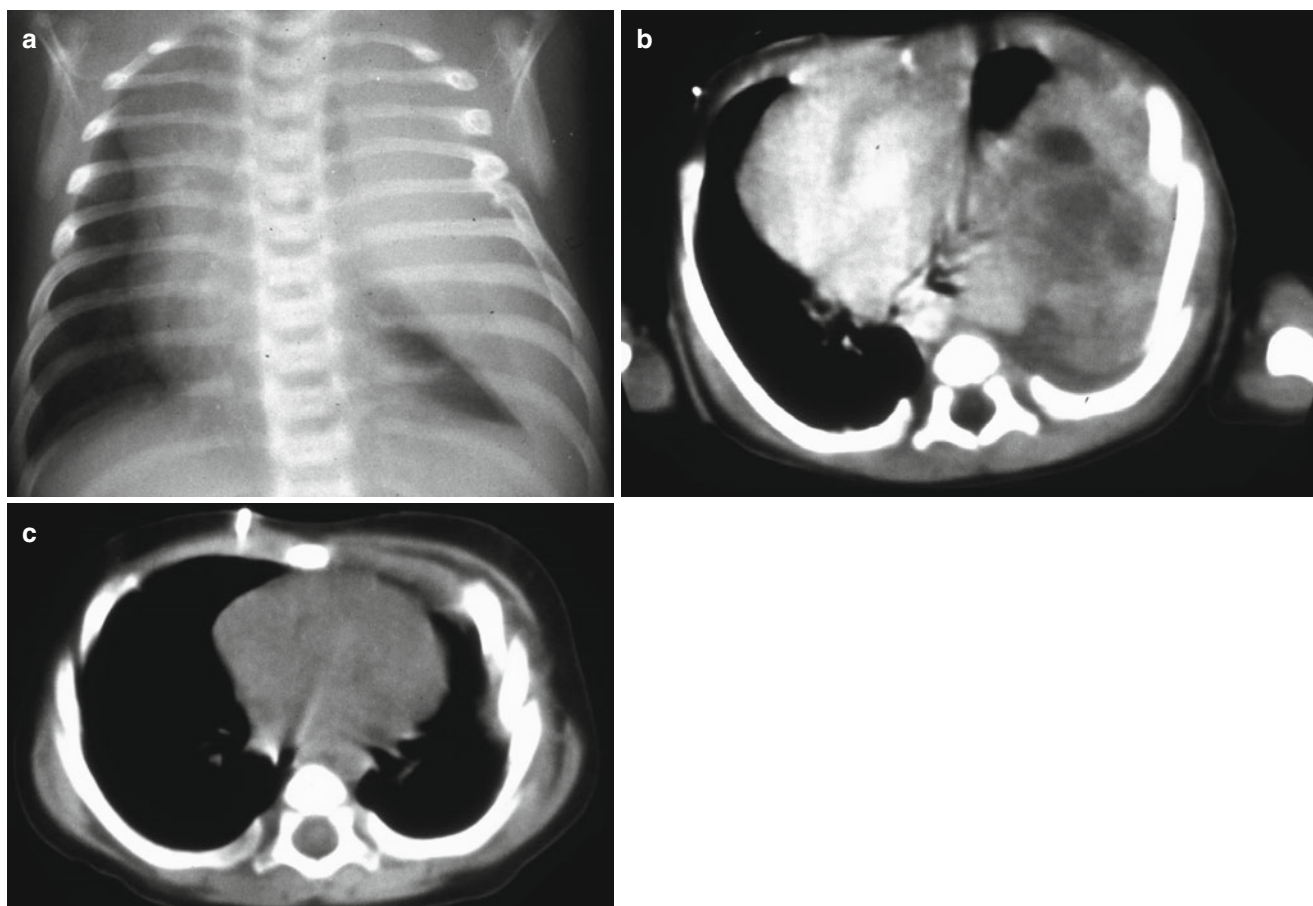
(a) Chest radiograph of a newborn with respiratory distress demonstrates a large left pleural “filling defect”. (b) CT scan demonstrated a solid lesion with some areas of presumed necrosis. Needle
